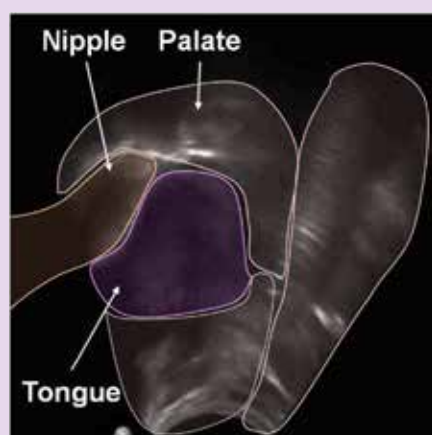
Submental ultrasound scans of the midline of the infant's oral cavity. The nipple and the infant's tongue and palate are labelled
